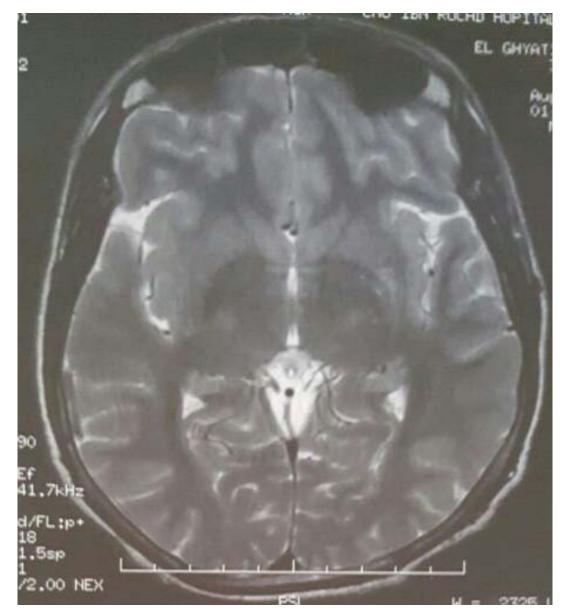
MRI of the brain and the cerebellar pontine angle was considered and showed no abnormalities
